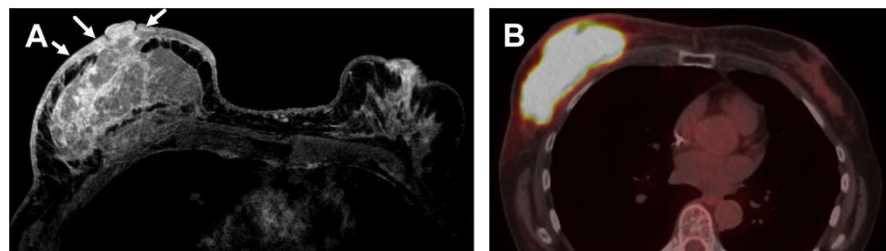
A 76-year-old woman with a self-palpated left breast mass, and core biopsy revealed triple-negative inflammatory breast carcinoma. (A) Contrast-enhanced breast MRI examination showed multicentric breast lesions with diffuse skin thickening and skin enhancement/lesions (arrows) secondary to biopsy-proven dermal tumor emboli. (B) PET/CT image revealed multicentric hypermetabolism throughout the right breast related to the IBC.
